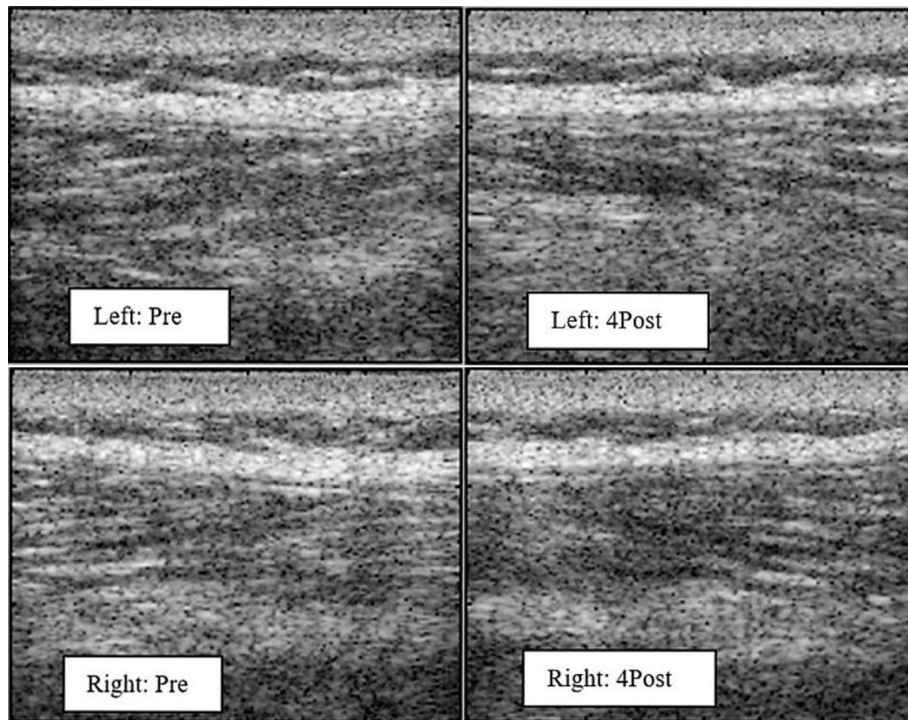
Ultrasound images showing connective tissue thickness change. Image on the left shows thickness before application of MELT. Image on the right shows thickness change 4 weeks after MELT.
